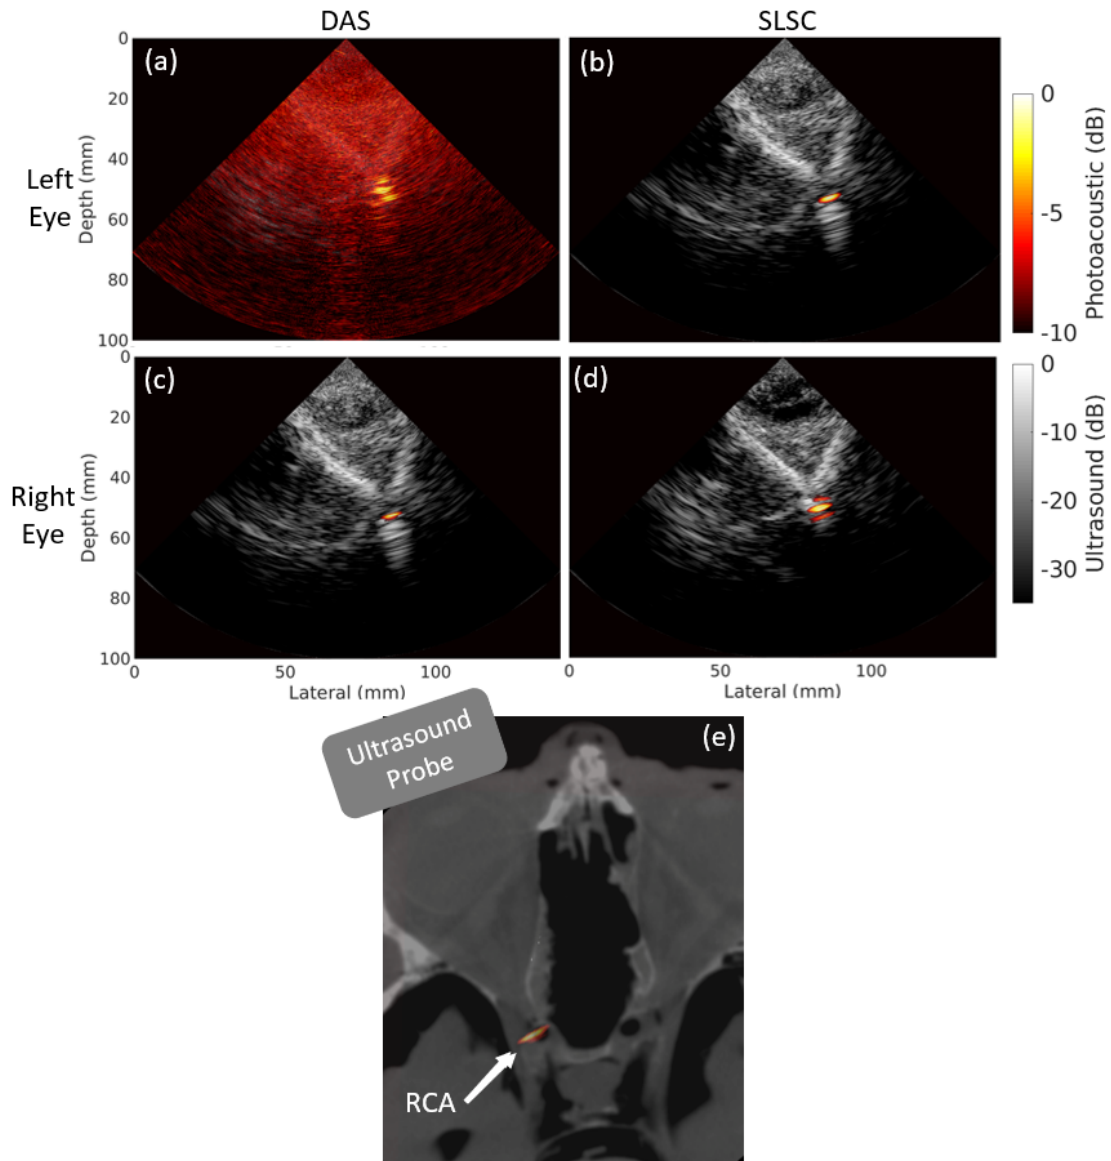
(a,c) DAS and (b,d) SLSC photoacoustic images from the fresh cadaver, overlaid on co-registered ultrasound images acquired with (a,b) left and (c,d) right ocular probe locations. The light source operated at 5.4 mJ per pulse and was placed on the LCA (visualized through the left eye) or RCA (visualized through the right eye). (e) Co-registered CT (gray scale) and photoacoustic image (color) images acquired with the ultrasound probe placed on the right eyelid of the cadaver head.
